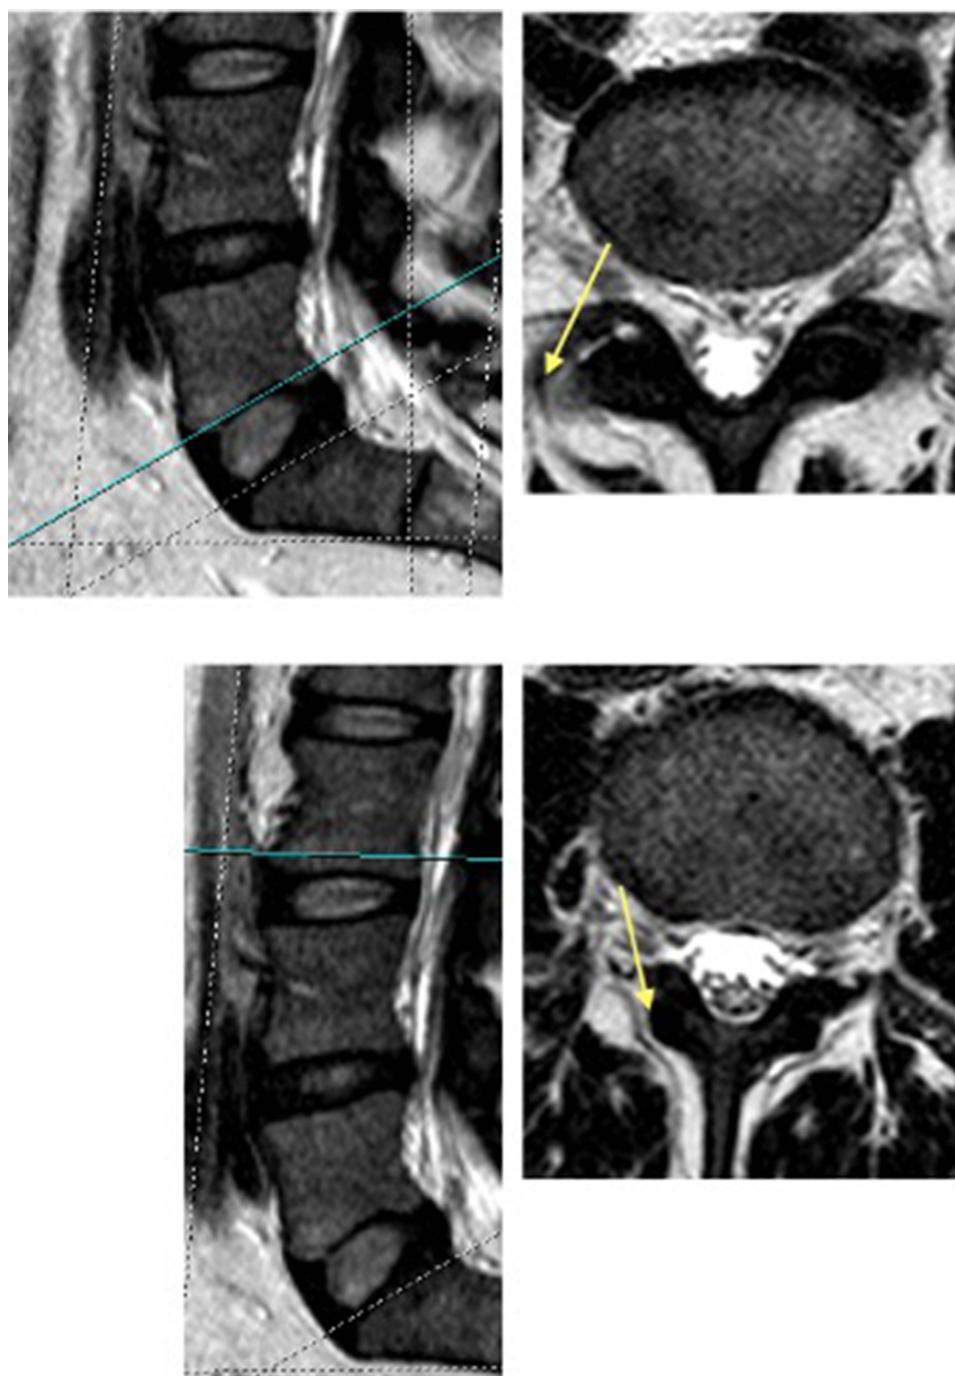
Comparison of anatomical lumbar anatomy on MRI. The sagittal cuts show the level of the corresponding axial cuts (L3 and L5) at the superior part of the foramen. Appreciate the variation in the anteroposterior angulation of the foramen between L3 and L5.
